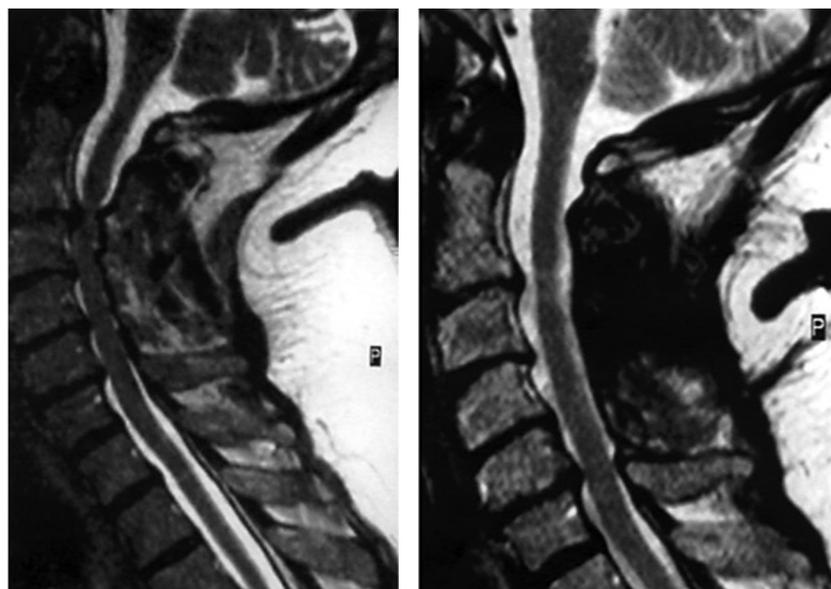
Sagittal MRI demonstrating pre-operative cervical spinal cord compression and following traditional cervical laminectomy at C3–4. Taken from Malcolm [5].
